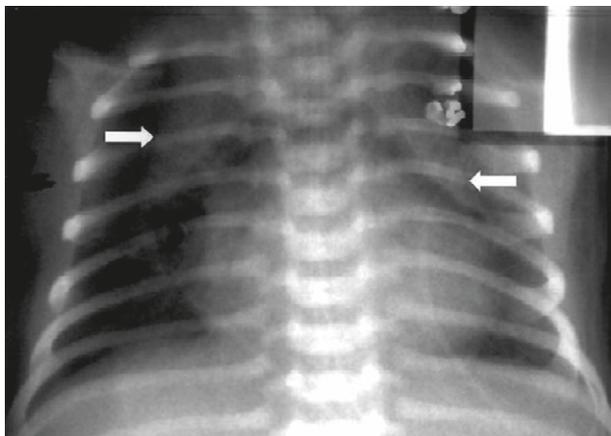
At 1 week old, a typical “spinnaker sail sign” (arrow) showed on supine anteroposterior chest roentgenogram.
